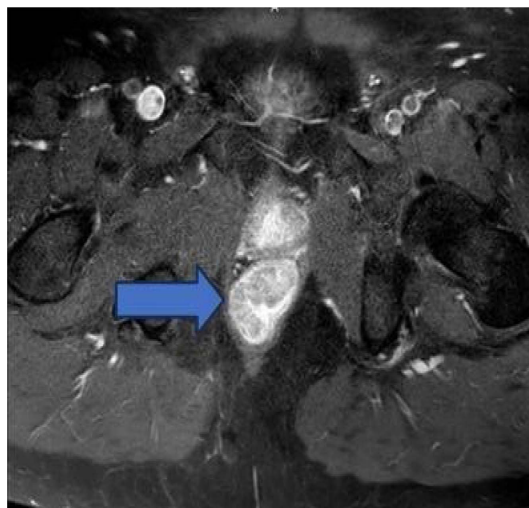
Axial and sagittal MRI slices showing a lower rectal lesion in, T2 hyper signal taking contrast heterogeneously with fat infiltration.
